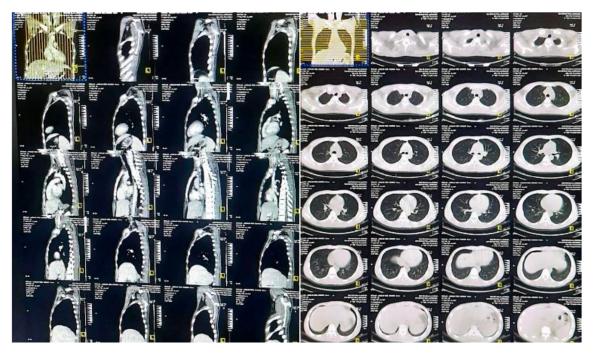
CT scan of the thorax with contrast.
